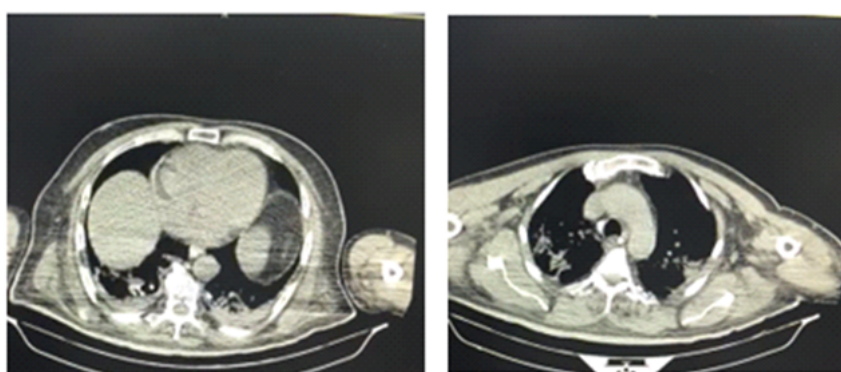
Computed tomography four days after treatment.
